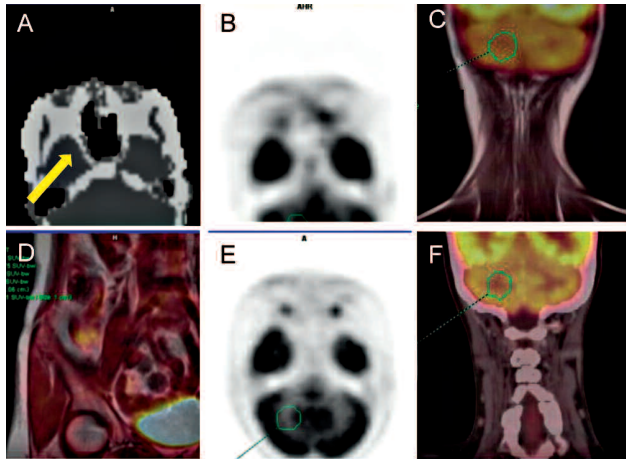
^{18}F -FDG PET/MR study of a 47 years old woman with breast cancer. (A) Misclassification error in brain in the attenuation map. (B, C) volume of interest (VOI) in right cerebellum for physiologic regional uptake in PET and PET/MR following Dixon-AC; SUVmean=3.82, SUR=5.38 (3.81/0.71). (D) VOI in right thigh muscle for reference; SUVmean=0.71. (E, F) VOI in right cerebellum in PET and PET/CT following CT-AC; SUVmean=5.86, SUVmean of right thigh 0.92 (figure is not included), SUR=6.37 (5.86/0.92).
